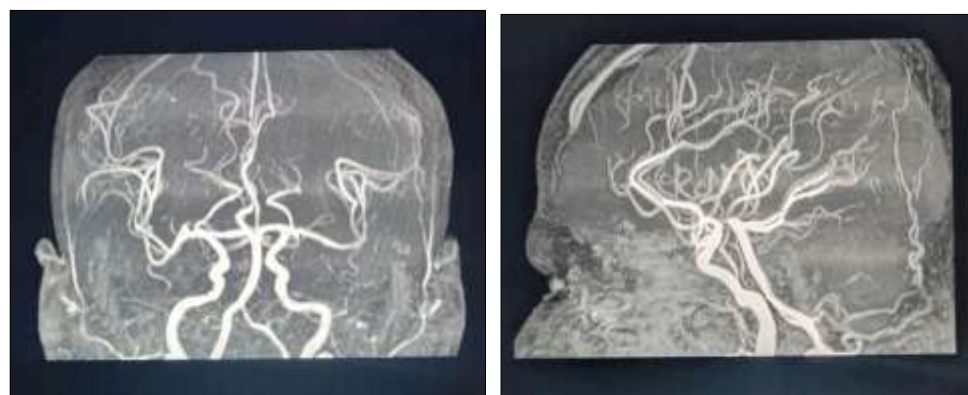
MRI Angiography of Brain Vessels Showing Normal Study
